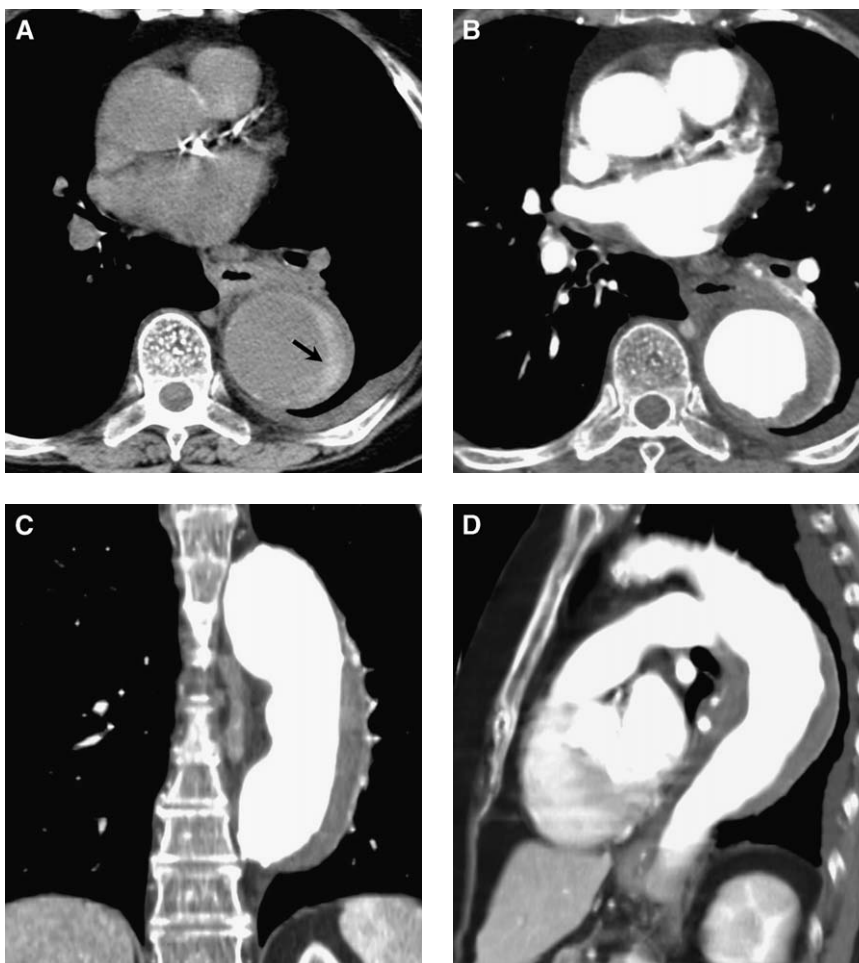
Aortic intramural hematoma (IMH). (A) On unenhanced CT, intramural hematoma is visible as a crescentic area (*arrow*) of increased attenuation in the aortic wall. (B) Following intravenous contrast administration, the intramural hematoma may be mistaken for thrombus within an aortic aneurysm. (C, D) On coronal and sagittal reformats, the intramural hematoma extends along the posterolateral wall of the descending aorta. IMH typically extends over a long segment of an aorta of normal caliber, whereas thrombus is usually seen along a short segment of a dilated aorta. The diagnosis of IMH requires visualization of displaced intimal calcification or increased attenuation of the aortic wall, both of which may be obscured by intravenous contrast material.
